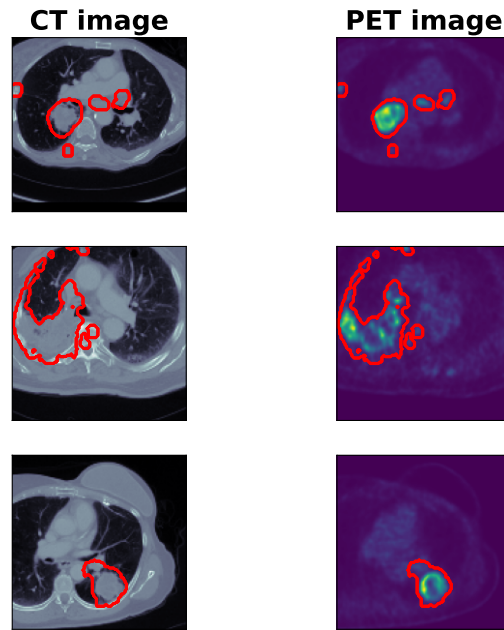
Examples of PET and CT patches of the same patient scan slices generated in the data preparation phase. The left column depicts CT patches, the right column visualizes PET patches, and the tumor annotations are depicted using red contour lines.
